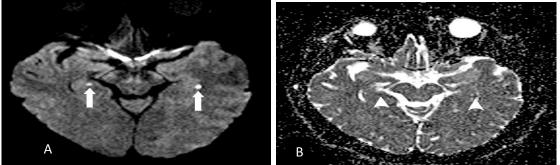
Axial brain MRI scan in a 61-year-old woman with an episode of two hours of anterograde amnesia that resolved completely. (A) diffusion weighted images (DWI) and (B) complementary apparent diffusion coefficient (ADC) map, depict two foci of restricted diffusion on both hippocampi, with high signal intensity in DWI (arrows) and low signal intensity in the ADC map (arrowheads).
